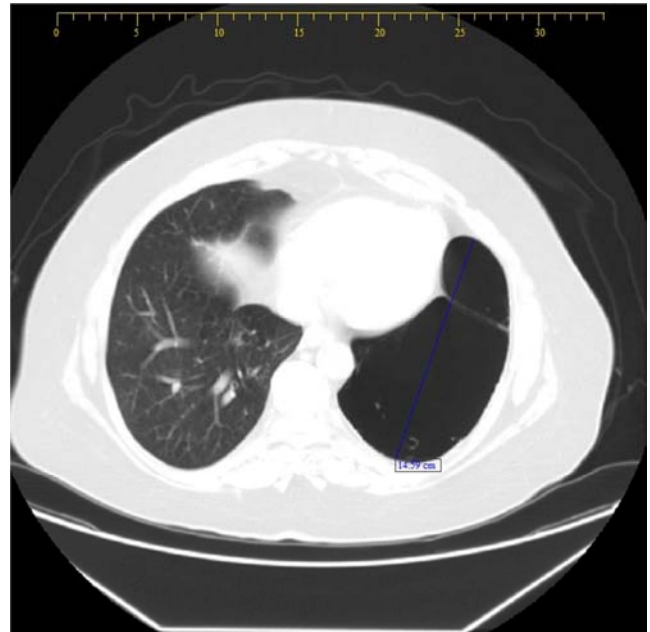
CT Scan demonstrating emphysematous changes and bronchiectasis present in the left lower lobe.
